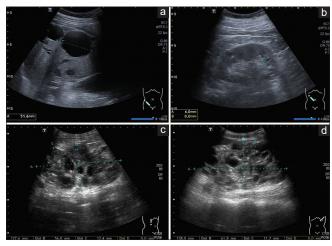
Ultrasonography (US) presentations of patients carrying *PRKCSH* or *LPR5* mutations. US in a 45-year-old man with *PRKCSH* mutations shows liver cysts (a) and few renal cysts (b). In a 42-year-old man carrying *LRP5* pathogenic mutations, US shows several small cysts in the right (c) and left (d) kidneys
